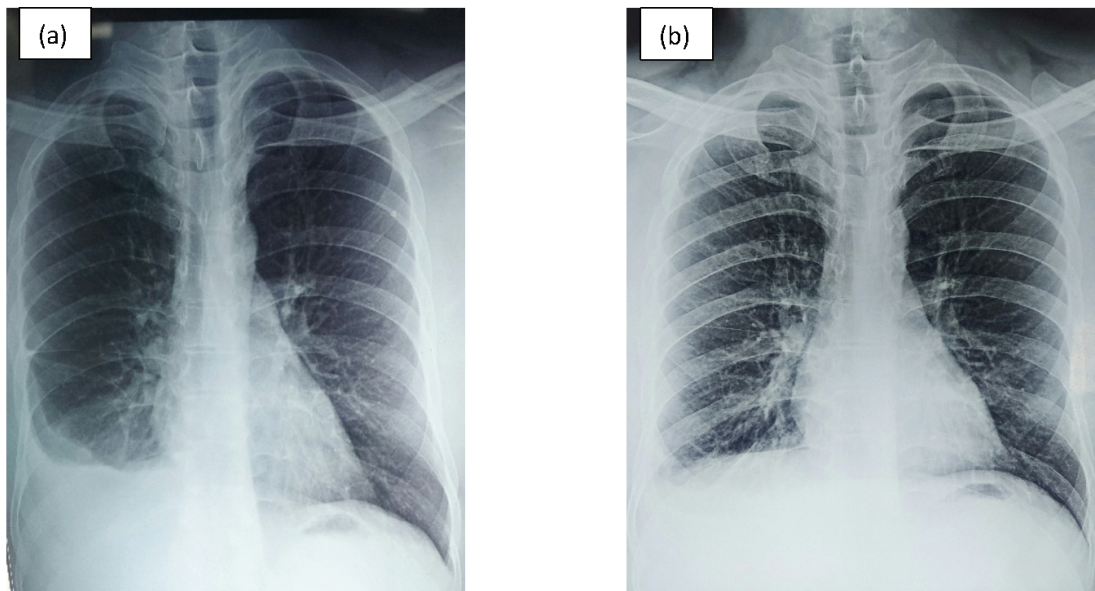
a) Chest radiography Posteroanterior (PA) view showing a homogenous opacity in the right lower zone blunting the right costophrenic angle. b) Follow-up chest radiography of the patient was taken after 4 weeks, and it showed significant resolution of pleural effusion.
